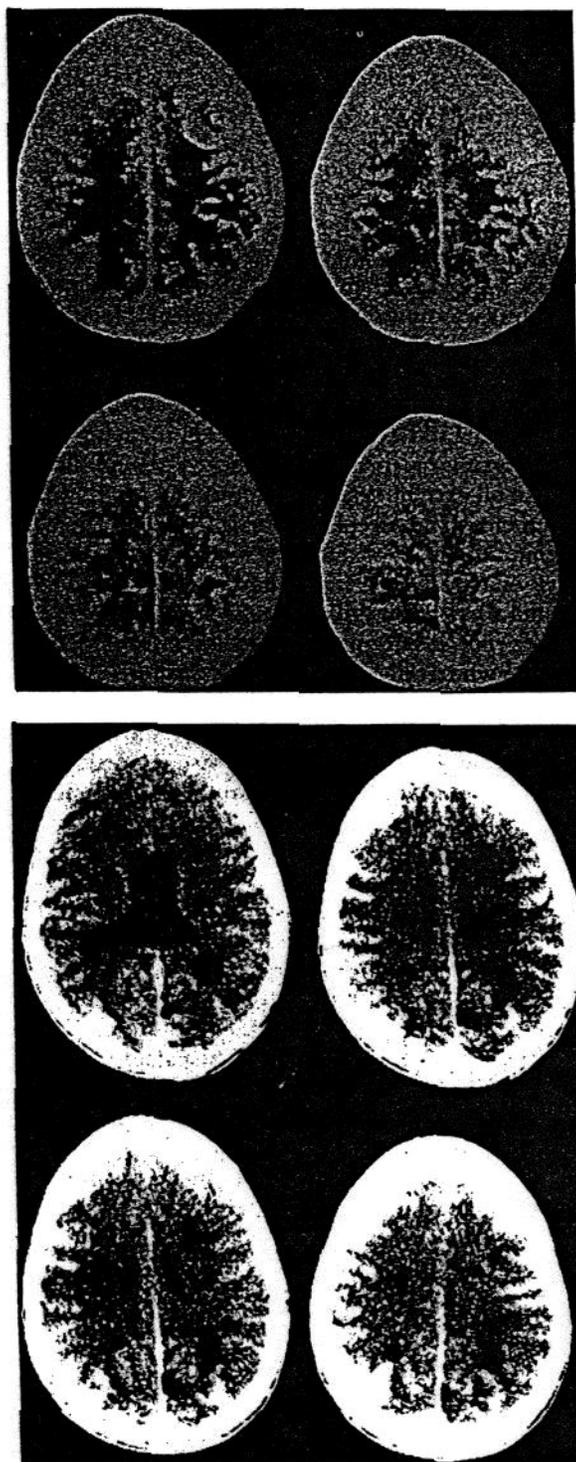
CT Scan of the Brain Obtained on the First Hospital Day — Upper Cranial Sections (Top), One-Hour Delay, High-Iodine, Showing Abnormal Generalized Gyriform Enhancement with Focal Left Frontal, Right Parietal, and Bilateral Parieto-Occipital Changes.
